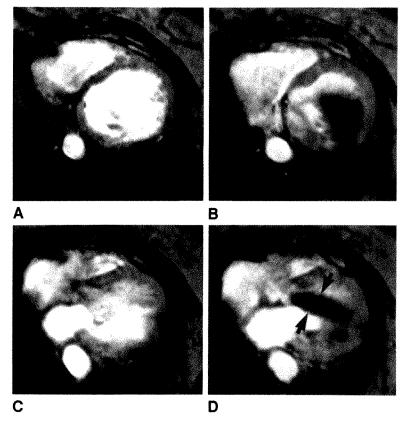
A, Cine MR image at midventricular level at enddiastole in patient with severe aortic regurgitation.
